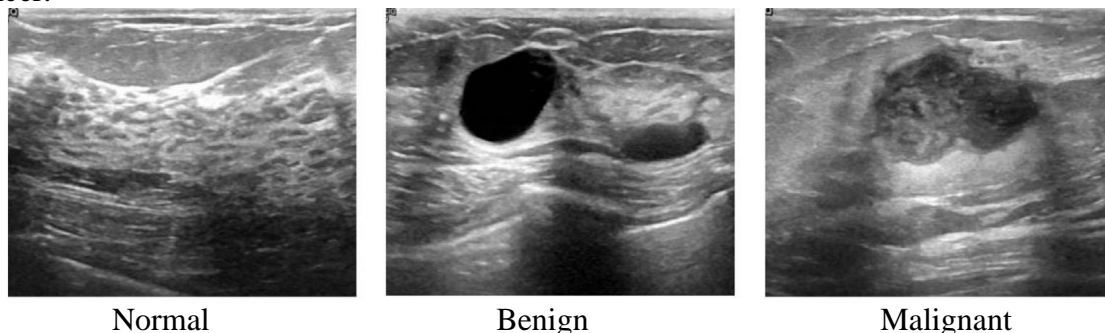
Sample Images from Breast Ultrasound Dataset [25]
